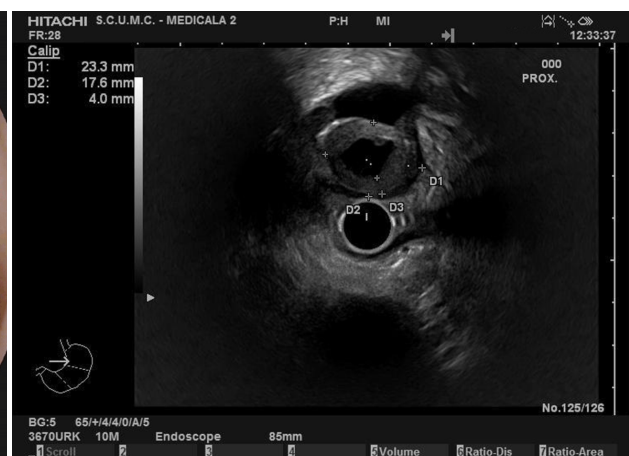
Endoscopic ultrasound of the lower intestine showed a tumor localized at the level of the recto-sigmoidian junction, approximately 23.3/17.6 mm in diameter, with a mixed structure, similar to the one located in the stomach: solid with a central transonic area inside.
